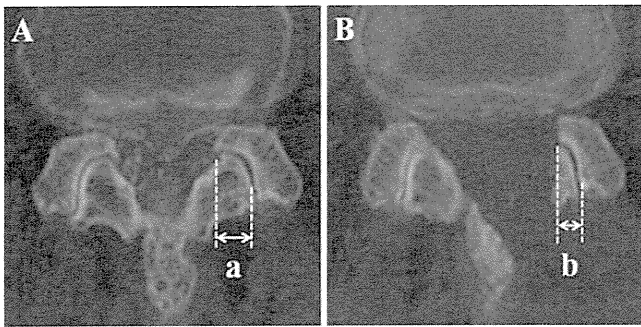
Measurement of facet joint preservation on preoperative (A) and at final follow-up (B) CT scans. The length of the facet joint was measured using Scion Image software, and the percentage of facet preservation was calculated using the following equation: (percentage of facet preservation) = $b/a \times 100$.
